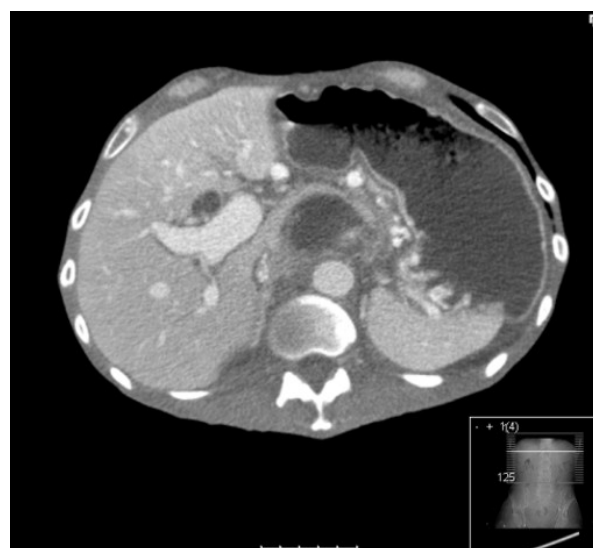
CT scan showing pseudotumoral cystic lesion in head of pancreas.
